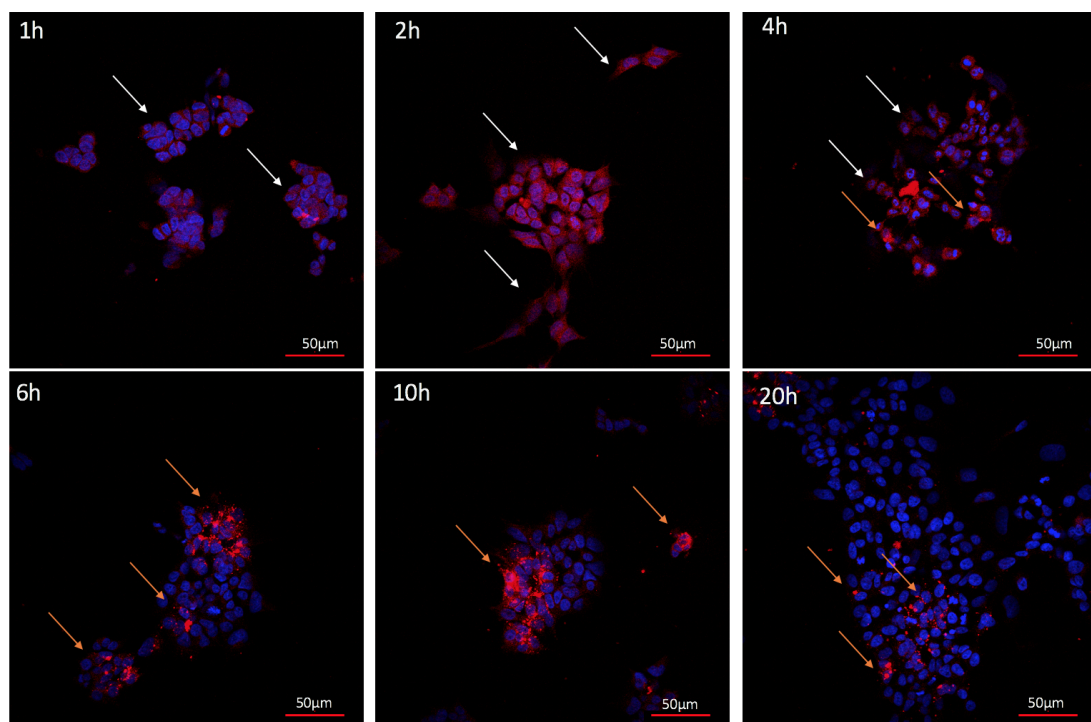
Exosome uptake over time evaluated by IF. Representative images of exosome uptake by cells at 37°C over 20 h time course. Red = CT (exosomes); blue = DAPI (nucleus). White arrows = exosomes on cell surface; orange arrows = exosomes as intracellular clusters. Scale bar = $50\ \mu\text{m}$.
